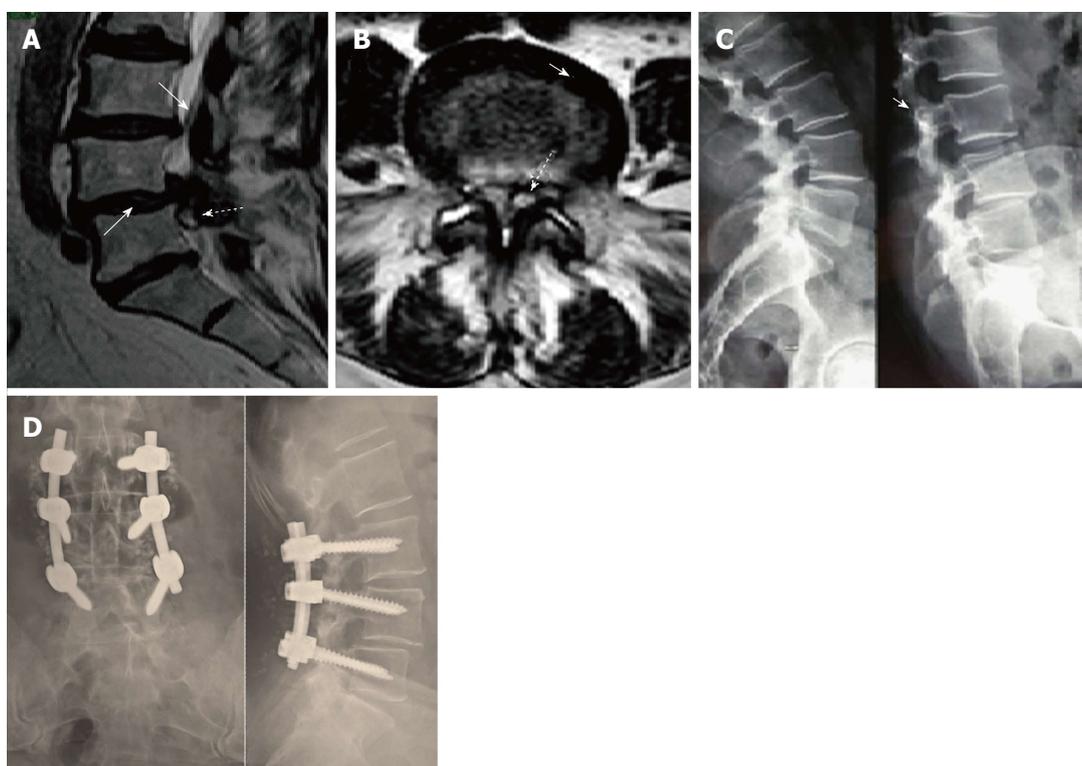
Case 12, Table 1. Preoperative sagittal T2-weighted MR image (A) showing a spinal ganglion cyst (dotted arrow) accompanied by olisthesis at L4/L5 with a dehydrated intervertebral disk (arrow), partially herniated into the spinal canal. On axial images (B) the cyst (dotted arrow) appeared to be of the medium or articular type (see text for classification). The interfacetal space contained an anomalous abundance of "sinovia" (commonly called synovial fluid), as the contralateral one did. Dynamic X-rays (C) showed an unstable olisthesis at L4/L5 and L3/L4. Postoperative outcome of the L3/L5 stabilization is documented by standard X-ray films (D) which confirmed good stability and fusion of the lumbar spine.
